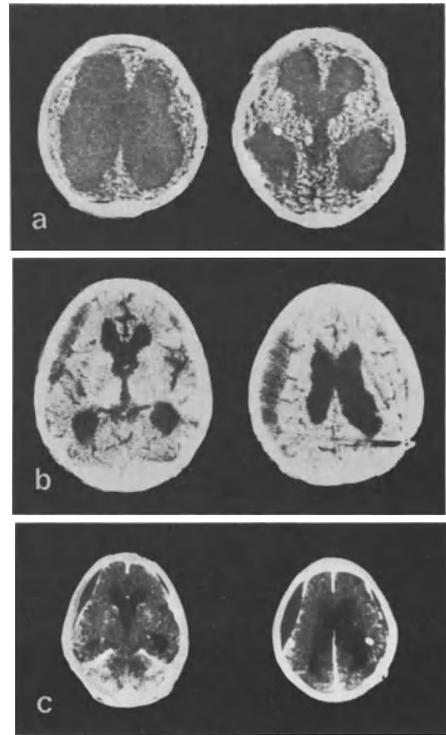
a-c. CT follow-up before (a) and after (b, c) CSF-drainage. Expecting attitude, adequate controls
